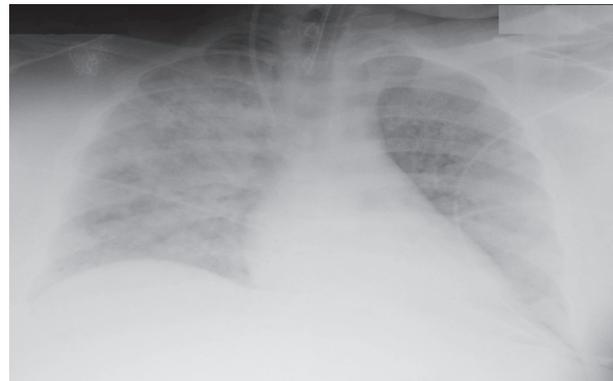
Chest X-ray following Intubation Showing Bilateral Diffuse Alveolar Syndrome Suggesting Pulmonary Edema
